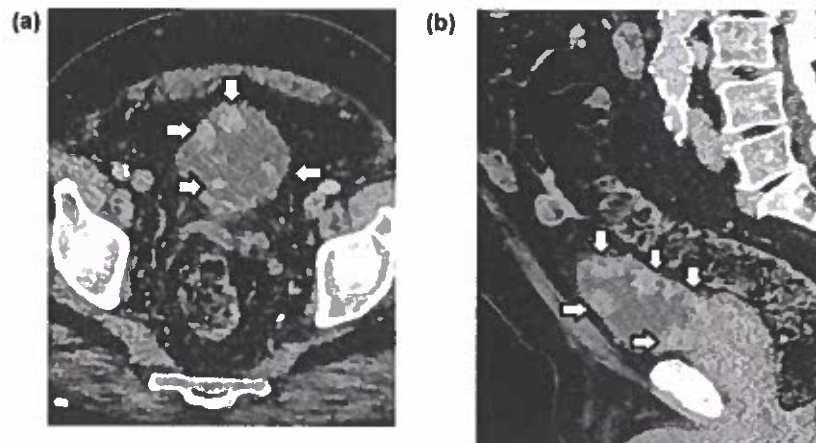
Multiple synchronous bladder carcinomas. Multiplanar reformations of contrast-enhanced CT images (portal phase) in (a) axial and (b) sagittal planes demonstrate multiple bladder tumors (arrows) as polypoid, contrast-enhanced masses.
